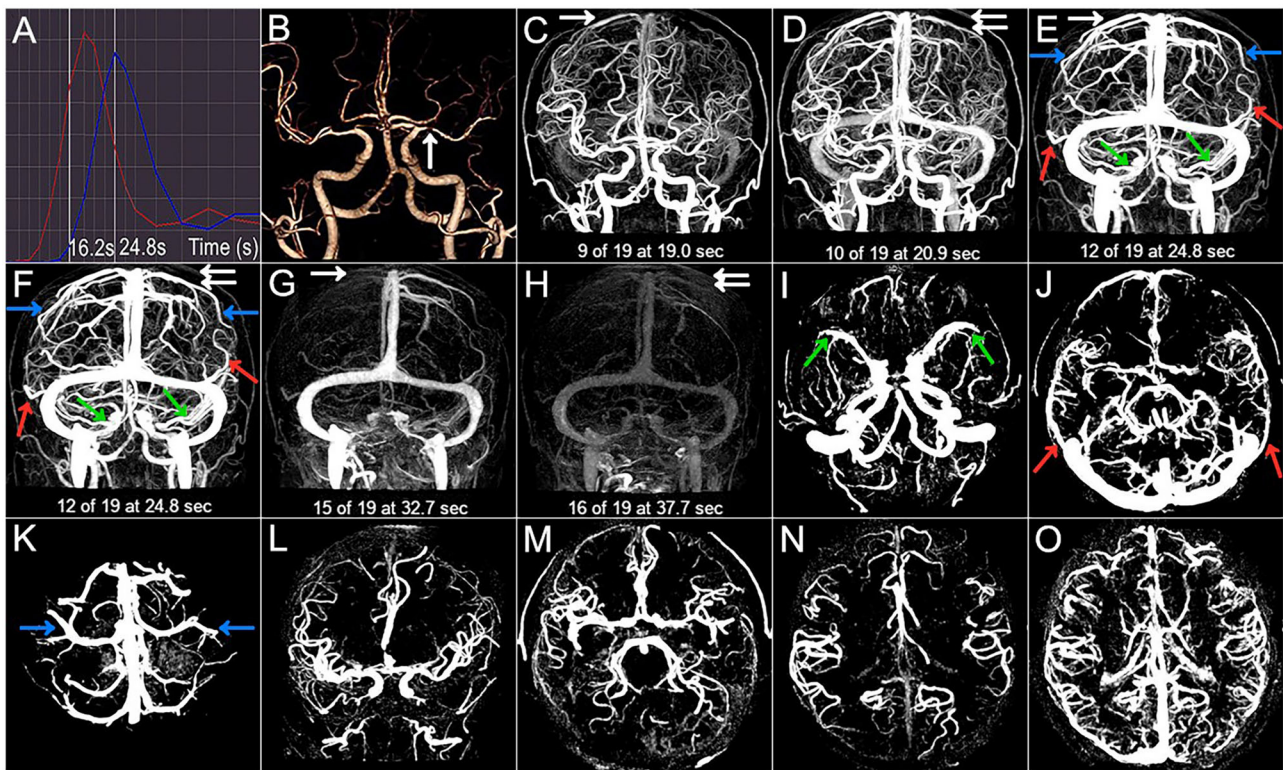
Case 1. A 66-year-old man with a history of hypertension and lipid disorder presented with dizziness for 3 days. (A) The arterial and venous time attenuation curves (TACs; red and blue, respectively). The selected arterial phase on TAC (A-TAC) was 16.2 s, and the time-to-peak on the venous TAC (V-TAC) was 24.8 s. (B) The arrow points to the left MCA M1 severe stenosis at A-TAC on three-dimensional (3D) computed tomographic angiography (CTA). (C–H) The 3D computed tomography venography (CTV) shows cortical venous filling (CVF) draining into the superior sagittal sinus at early (CVF₁), peak (CVF₂), and late venous phases (CVF₃) in the affected (double white arrow) and contralateral (white arrow) hemispheres. Cortical veins begin to be visible in the contralateral (C, CVF₁, 19.0 s) and affected hemispheres (D, CVF₁, 20.9 s). The maximum contrast opacification of all cortical veins in the contralateral (E, CVF₂, 24.8 s) and affected hemispheres (F, CVF₂, 24.8 s) appear at the same time, and contrast medium in all cortical veins disappears in the contralateral (G, CVF₃, 32.7 s) and affected hemispheres (H, CVF₃, 37.7 s). CVF₂₁ and CVF₃₁ of the contralateral hemisphere are 5.8 s and 13.7 s, respectively, while the CVF₂₁ and CVF₃₁ of the affected hemisphere are 3.9 s and 16.8 s, respectively. The mean difference between the affected and contralateral hemispheres is 1.9 s for rCVF₁, 0 s for rCVF₂, 5 s for rCVF₃, –1.9 s for rCVF₂₁, and 3.1 s for rCVF₃₁. The presence (color arrow) and absence (circle) of SMCV (green), VOL (red), and VOT (blue) across all whole venous phases (marked as SMCV+/VOL+/VOT+ and SMCV-/VOL-/VOT-, respectively) are displayed in the 3D CTV and (I–K) axial planes of the V-TAC. SMCV-, VOL-, and VOT- are not found in the bilateral hemispheres. (L,M) Antegrade flow assessment at TAC in the coronal and axial planes. Contrast filling of the MCA M1 segment and its distal branches in the affected hemisphere is more than two-thirds of the contralateral hemisphere, the contralateral hemisphere, and antegrade flow is preserved. (N,O) Collateral status assessment at A-TAC and V-TAC in the axial plane. Complete contrast enhancement of collateral flow at V-TAC in the affected hemisphere with good collateral status.
